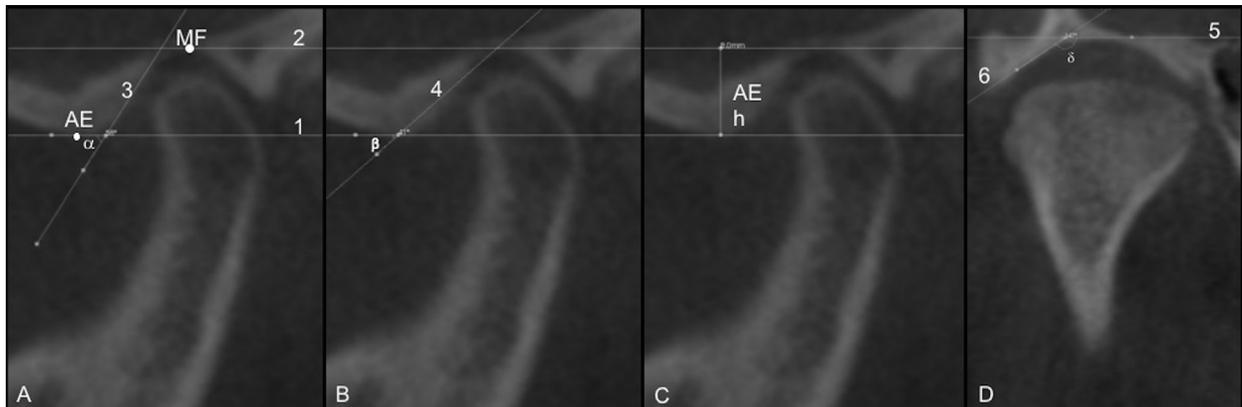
Articular eminence and mandibular fossa measurements in a brachycephalic female patient. (A–C), Cone beam computed tomography (CBCT) sagittal reconstructions showing measurements of articular eminence inclination ( $\alpha$  and  $\beta$  angles) and height. (D), CBCT coronal reconstruction showing measurement of the lateral inclination of the mandibular fossa ( $\delta$  angle).
